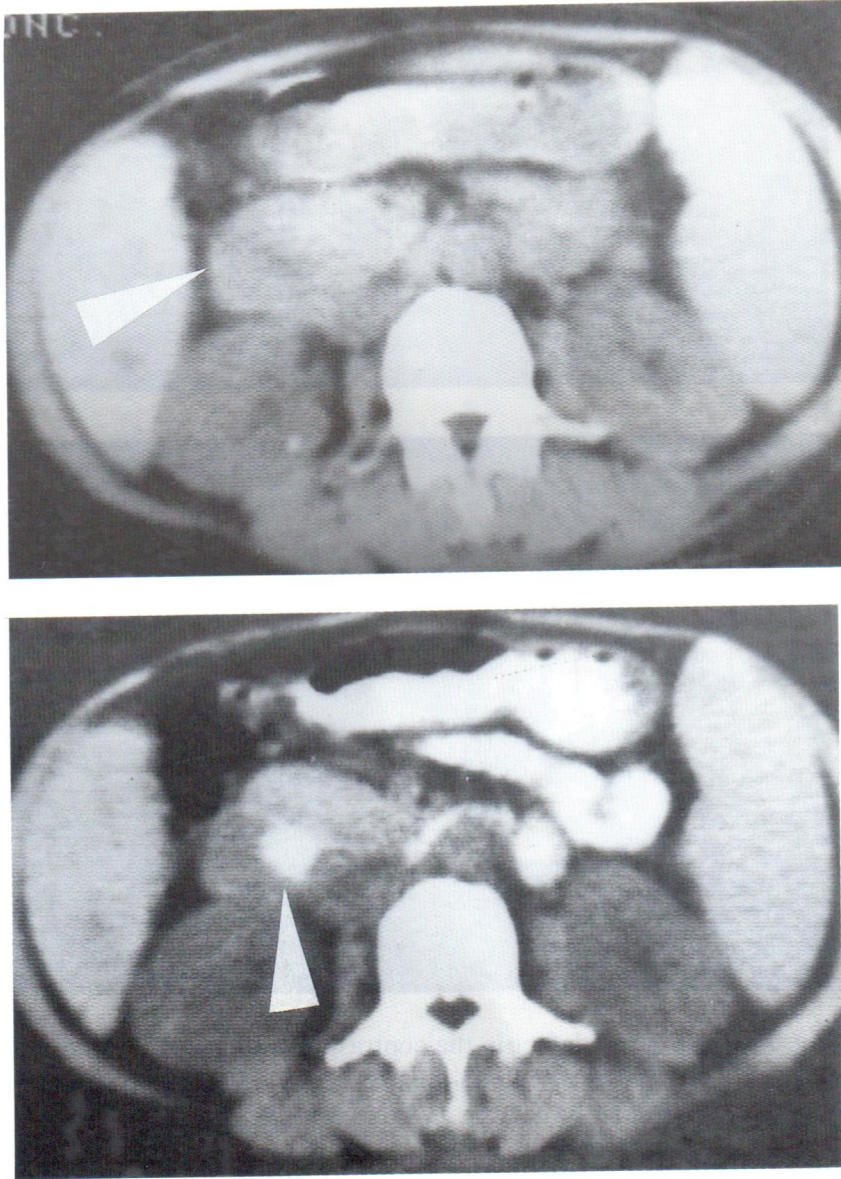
Plain CT scan showed bulging contour of the pancreatic head with a faint low density area in the center represent CBD. Oral contrast filled CBD was seen in the center of the bulged pancreatic head.
